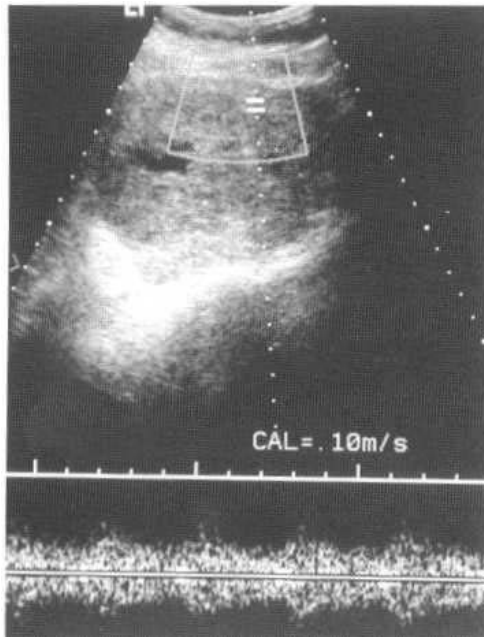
TAS. Large malignant germ cell tumour in a 25-year-old. Doppler shows typical low impedance flow with RI of 0.5.
